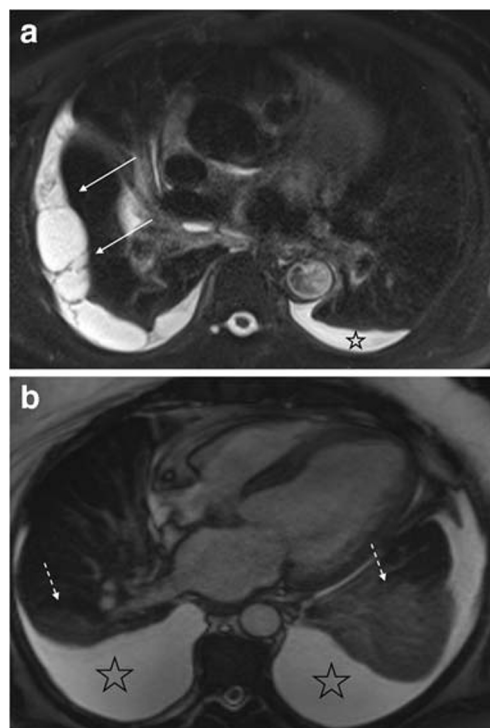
a Axial fat-saturated T2-weighted image mildly complex right pleural effusion with loculations and internal T2 hypointense septations (white arrow) and simple left pleural effusion (star). b Axial steady-state free precession image, in a different patient, shows moderate-sized layering simple pleural effusions (stars) with associated adjacent compressive atelectasis which is uniformly mildly hyperintense (dashed white arrows)
